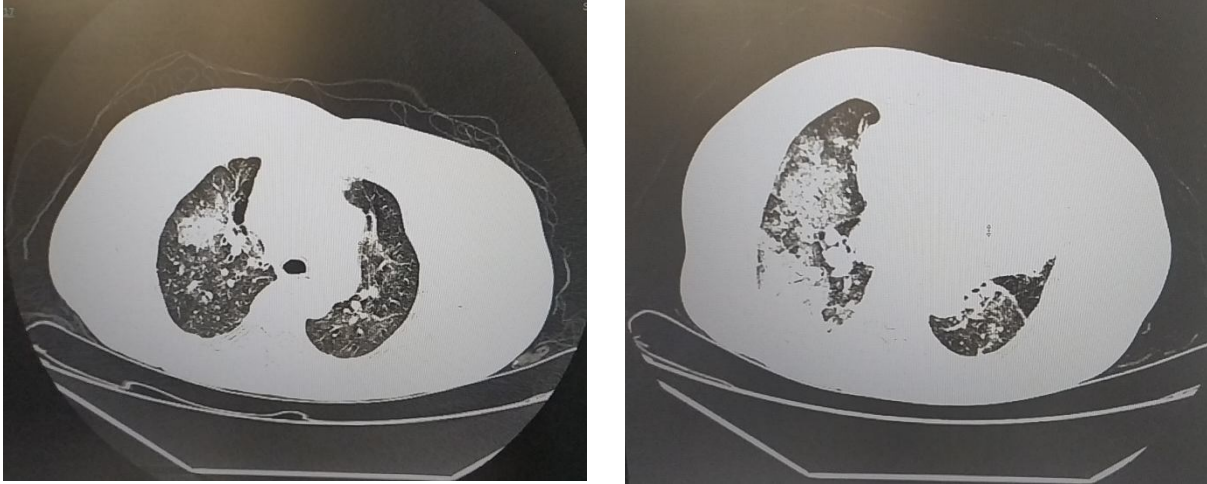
CT Chest showing confluent patches of consolidation in the right lung with the air-space nodular opacity in bilateral lungs indicates likely infective, cardiomegaly, and few prominent mediastinal lymph nodes (Day 1).
